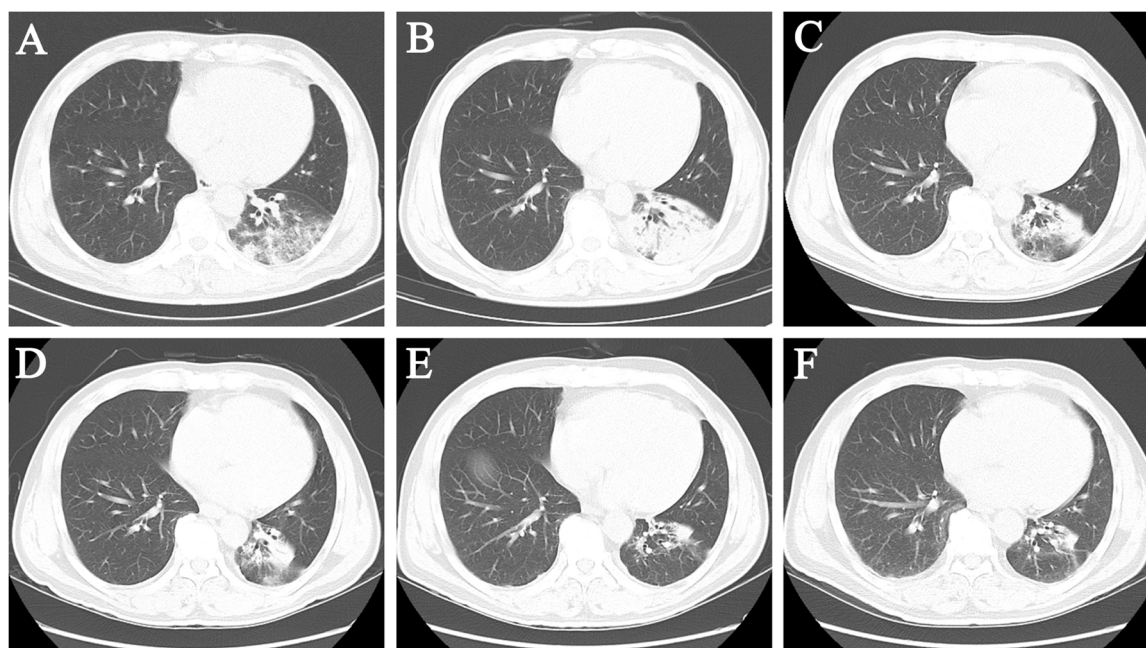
Chest computed tomography scan at admission (A), 12d later (B), 21d later (C), 33d later (D), 40d later (E), and 54d later (F).
